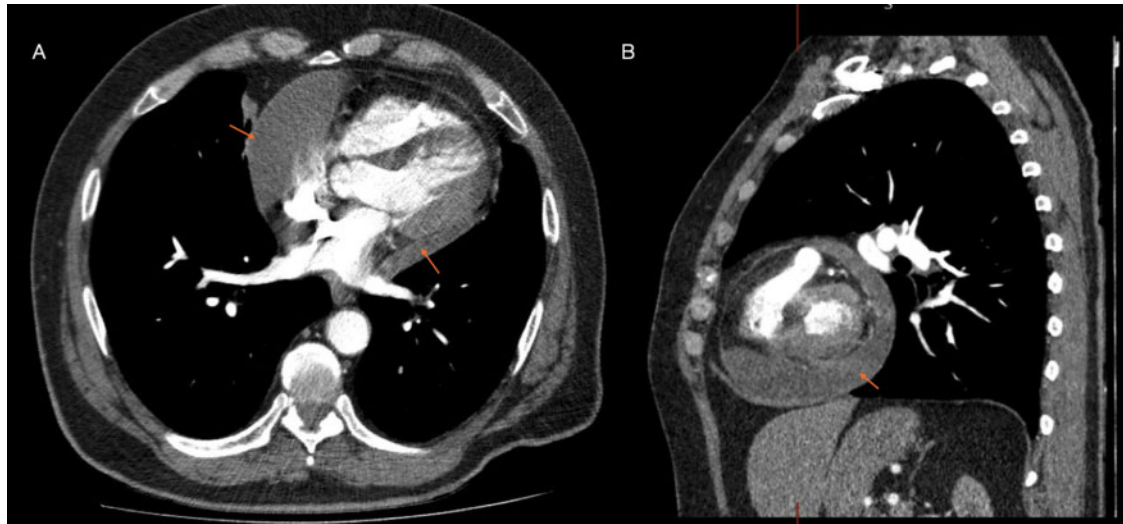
Contrast enhanced computed tomography thorax abdomen and pelvis in arterial phase with soft tissue windowing demonstrating the incidental encysted pericardial effusion (arrowed) in axial plane (A) and sagittal plane (B).
